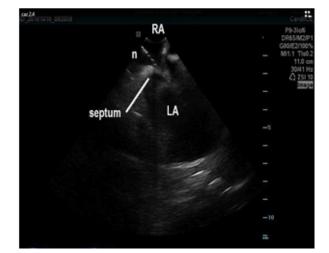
Intracardiac echocardiography during catheter ablation of atrial fibrillation. The transseptal puncture is guided by ICE to obtain access to the left atrium. The white arrow indicated the transseptal needle against the interatrial septum at the level of fossa ovalis. The "tenting" of the interatrial septum signifies a stable contact of the needle with the fossa ovalis.
